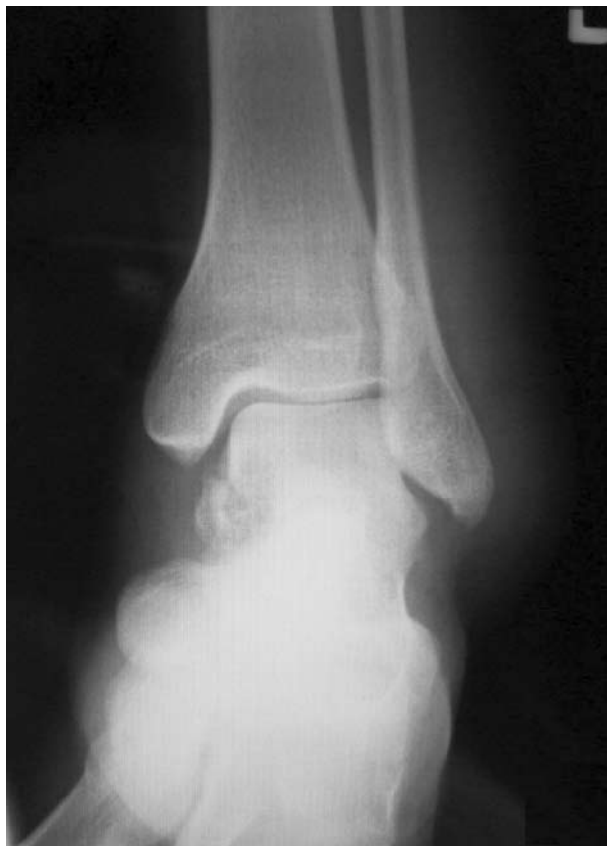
Anteroposterior x-ray image showing ankle joint with inhomogeneous transparency in the area of medial talus.
